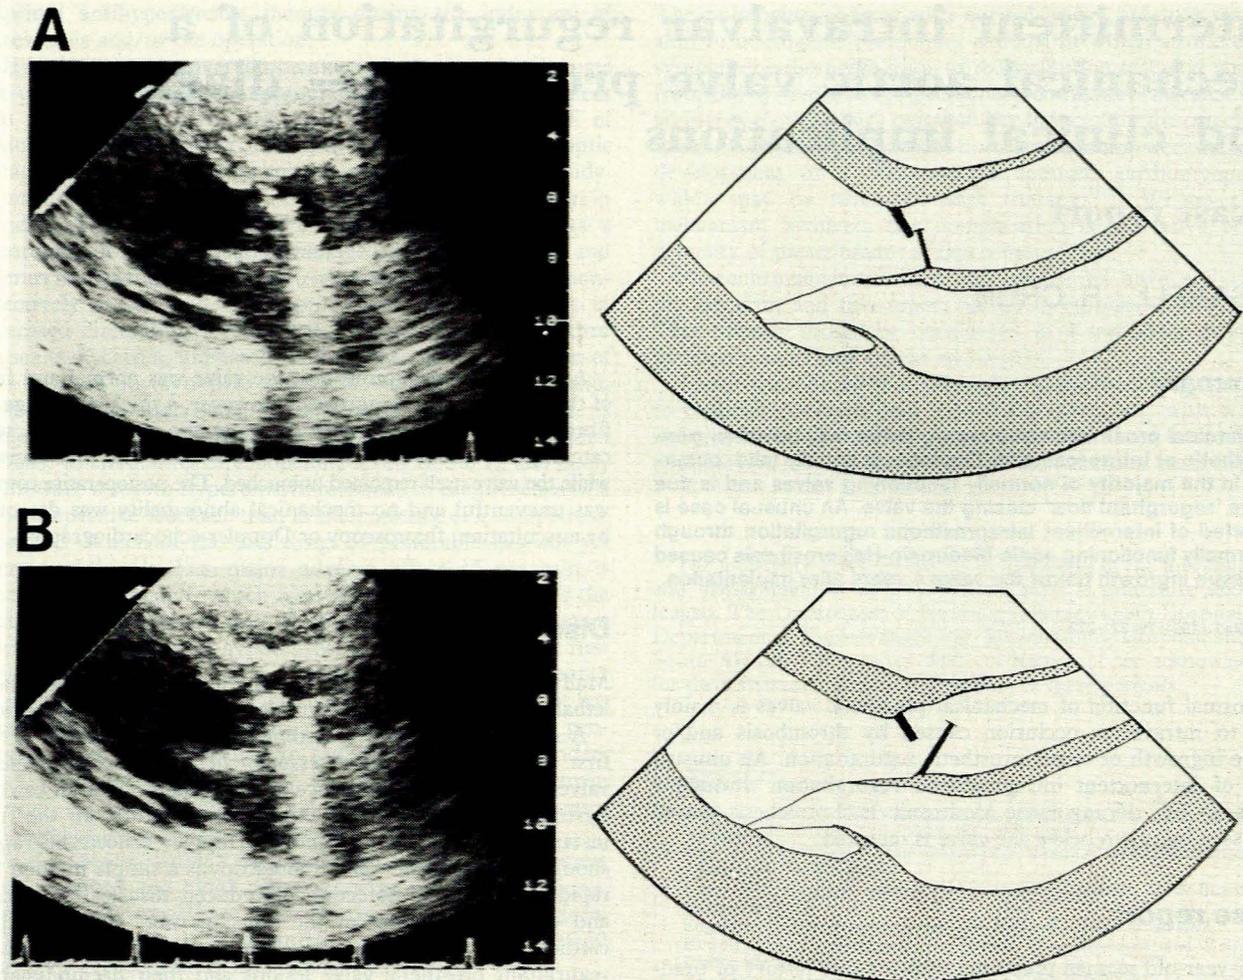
Two-dimensional echocardiograms in the left parasternal long axial view taken in diastole (mitral valve leaflets in open position). A. The tilting disc of the prosthetic aortic valve is in the normal closed position during diastole. B. The disc is 'stuck' in the open position during diastole.
